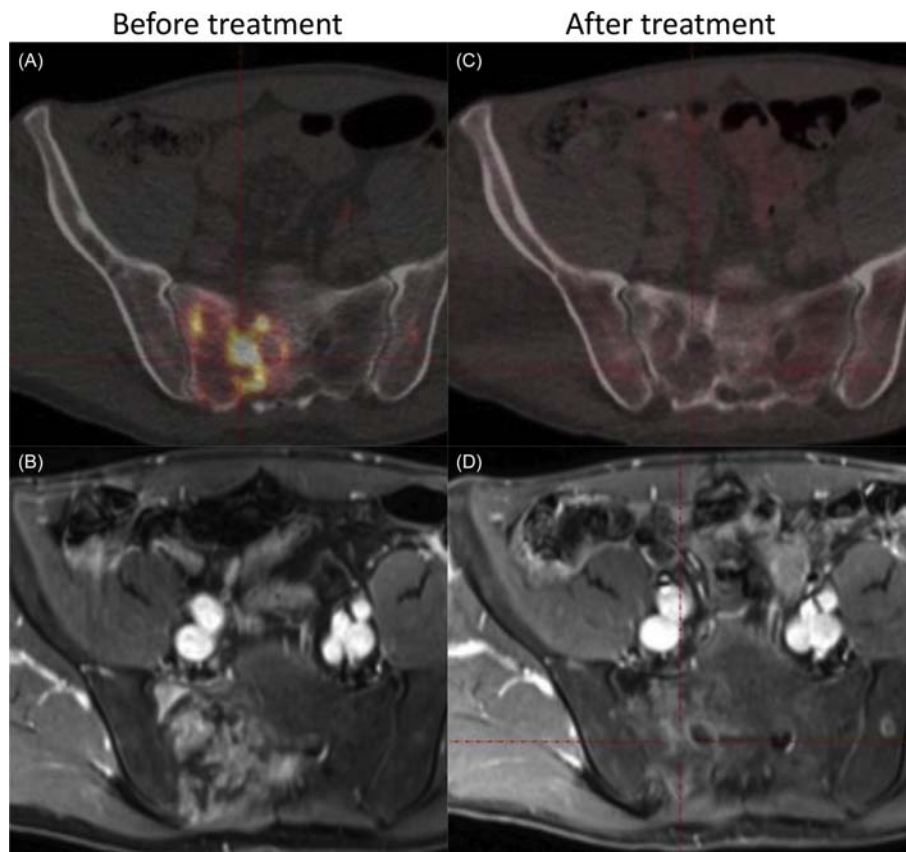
FDG-PET/CT (A and C) and contrast-enhanced, fat-suppressed T1-weighted MRI (B and D) in a patient with a large, destructive myeloma infiltrate in the right sacral bone, obtained before (A and B) and after (C and D) high-dose chemotherapy with stem cell support. Initially, there is intense contrast enhancement and marked FDG uptake, both being markedly reduced after treatment. Courtesy of Dr. Bettina Beuthien-Baumann, Heidelberg.
